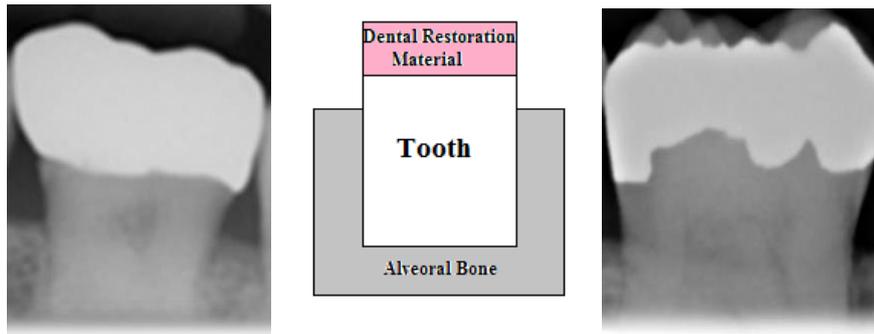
Tooth and restoration material: *Middle picture*) FLUKA and MCNPX geometry *Outside pictures*) Radiographic image [9]
